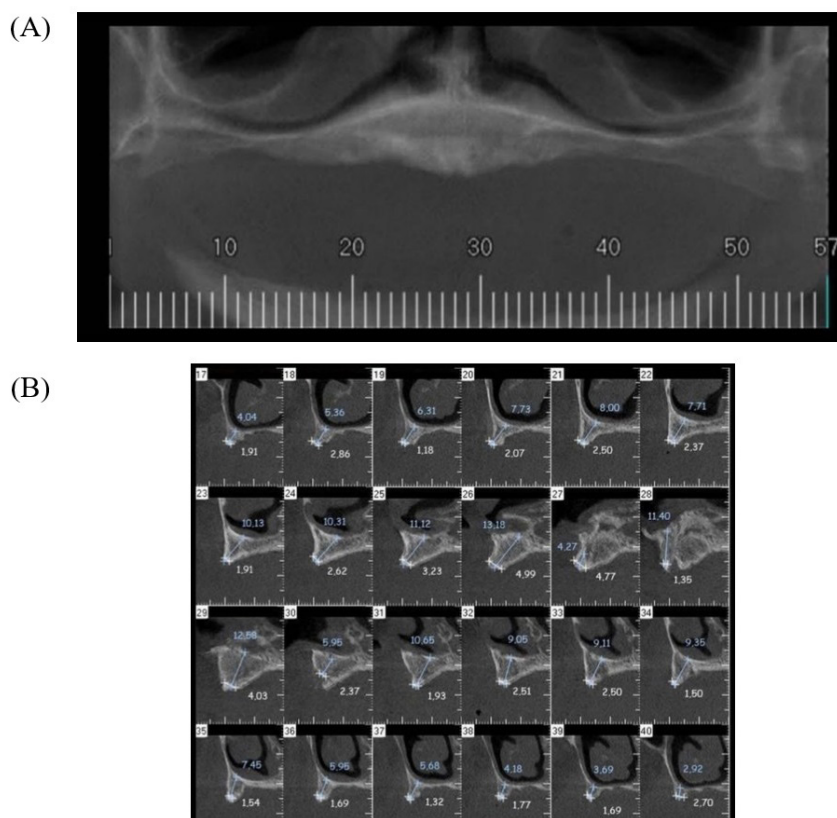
Patient's imaging exams. (A) panoramic image reconstruction of the CBCT, showing height loss; (B) trans-axial slices from the CBCT showing thickness and height loss.
